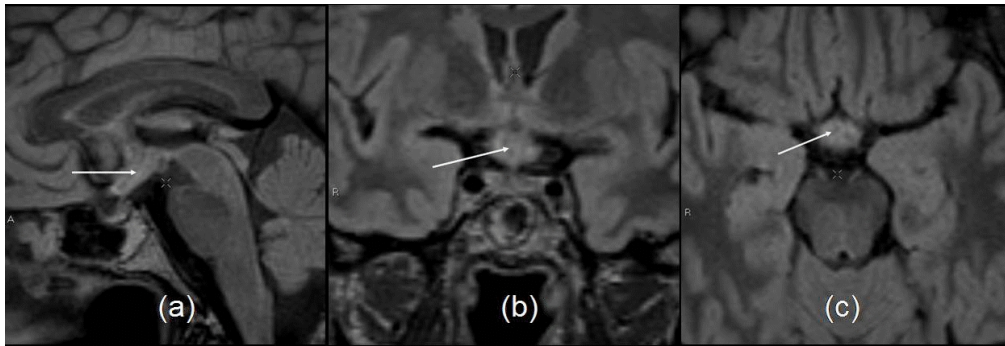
3D FLAIR images in (a) sagittal, (b) coronal and (c) axial reconstructions, showing epidemoid cyst (white arrow) as an area of intermediate signal, within the third ventricle.
